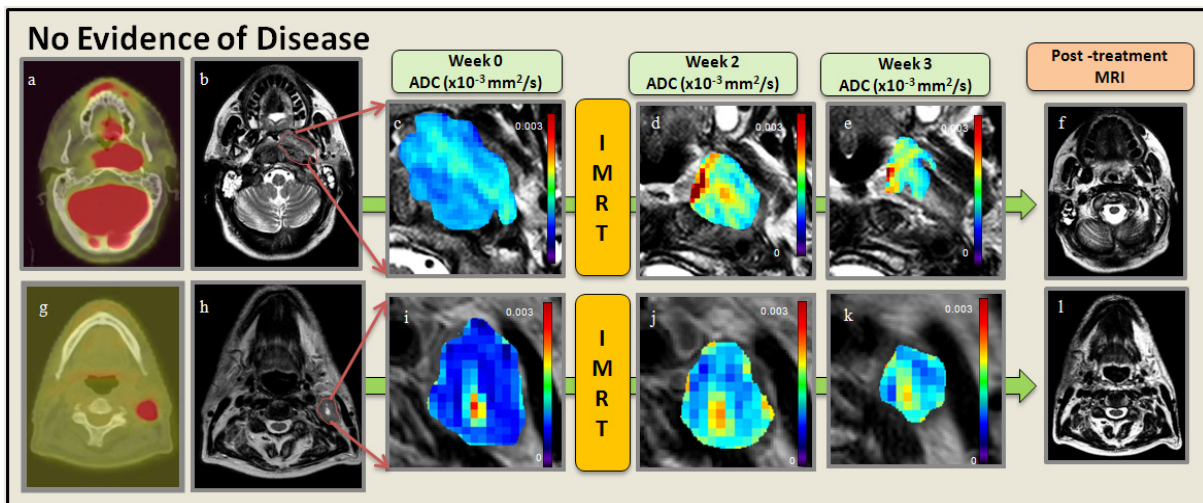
Representative NED patient. a. and g. pre-Tx PET/CT of the primary tumor and a neck nodal metastasis. b. and h. Primary tumor and representative neck nodal metastasis contoured over a T2W MRI. c. and i. pre-Tx ADC map overlaid on T2W MRI. d. and j. Wk2-Tx ADC map overlaid on T2W. e. and k. Wk3-Tx ADC map overlaid on T2W. f. and l. T2W MRI post-Tx with no evidence of primary tumor and neck nodal metastases.
